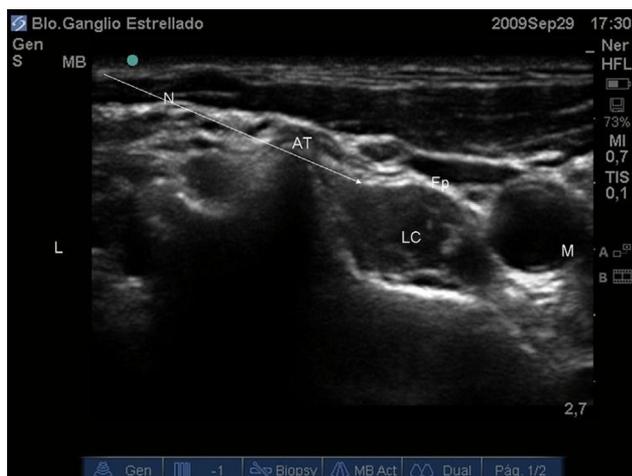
Short-axis transverse ultrasound image showing the needle path to the prevertebral fascia (Fp) for stellate ganglion block. N, needle path; AT, anterior tubercle; LC longus colli muscle; M, medial; L, lateral. (Color version of figure is available online.)
